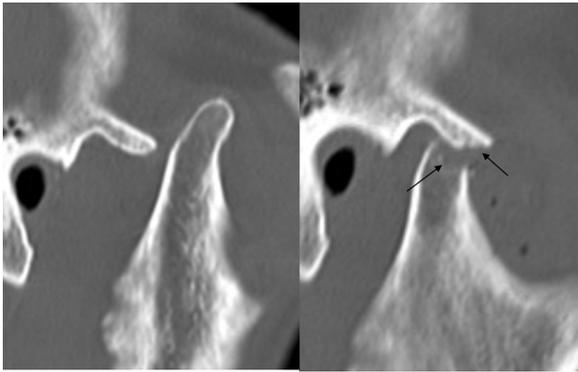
Complete reduction (case 1) before (left) and after reduction (right) on computed tomographic scans of long-standing dislocation of the right temporomandibular joint. The arrows indicate bony surfaces after eminectomy and condylectomy.
